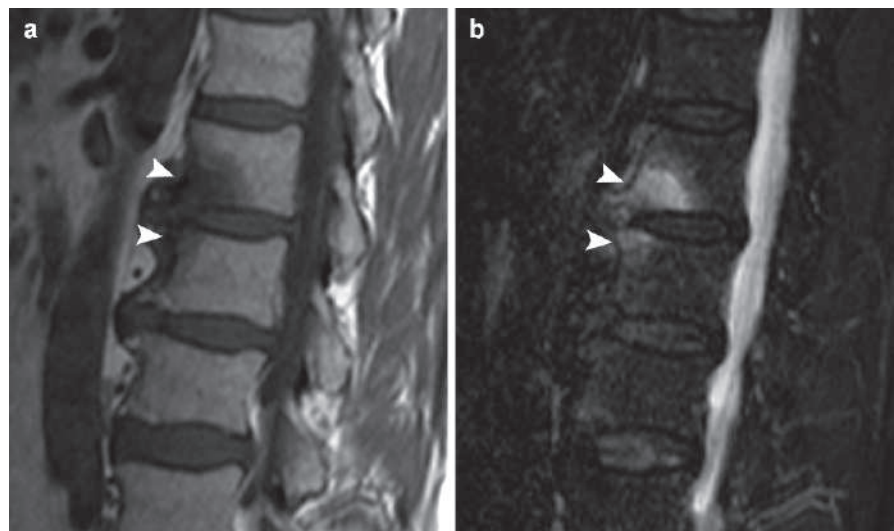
Sagittal thoracic T1W (a) and STIR (b) MRI show enthesitis at the anterior superior and anterior inferior vertebral endplates of two adjacent vertebrae (Romanus lesion) (arrowheads)
